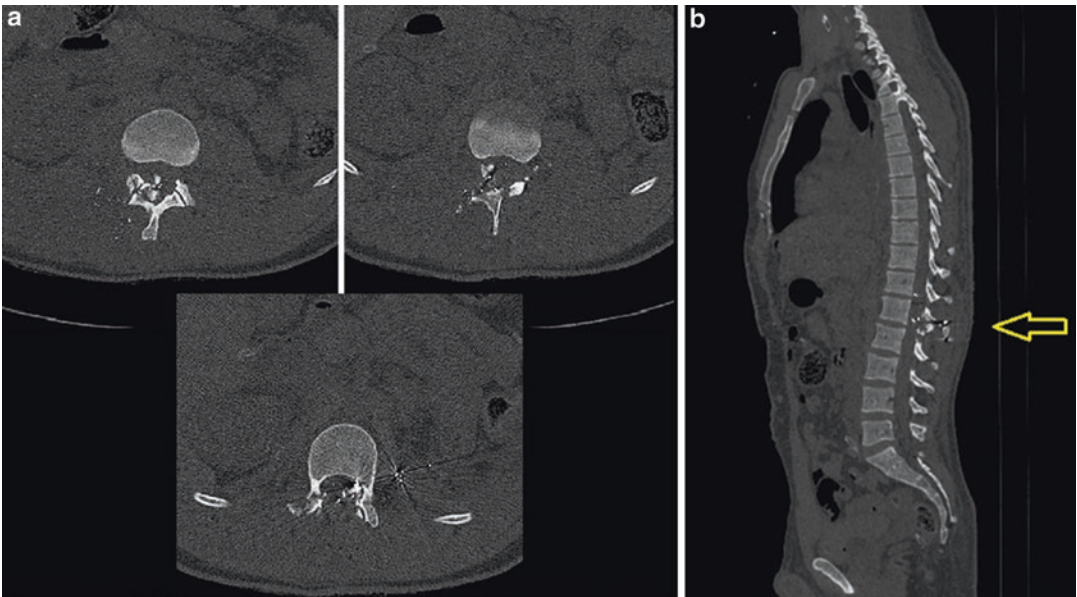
(a) CT of thoracolumbar spine, axial cut: Comminuted fracture involving the posterior arch of L1 and L2, bilateral pedicle fracture at L1 and right pedicle fracture at L2, right transverse process fracture of L1, L2, and L3. Several shrapnel in the spinal canal and in the overlying soft tissue as well as in the left psoas muscle.
